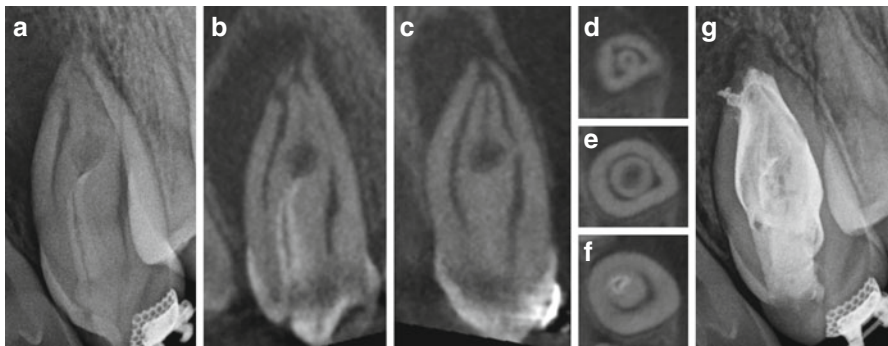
Preoperative periapical radiograph of a maxillary left lateral incisor presenting with dens invaginatus (a). Coronal and sagittal CBCT slices (b, c) as well as axial CBCT slices captured from the apical third (d), mid-root (e), and coronal third (f) demonstrate the complex anatomical configuration of the developmental anomaly. Post-endodontic periapical radiograph demonstrates proper management of the root canal spaces (g) (Case courtesy of Dr. Hong Chon, Specialized Endodontic Solutions, Bloomingdale, IL)
